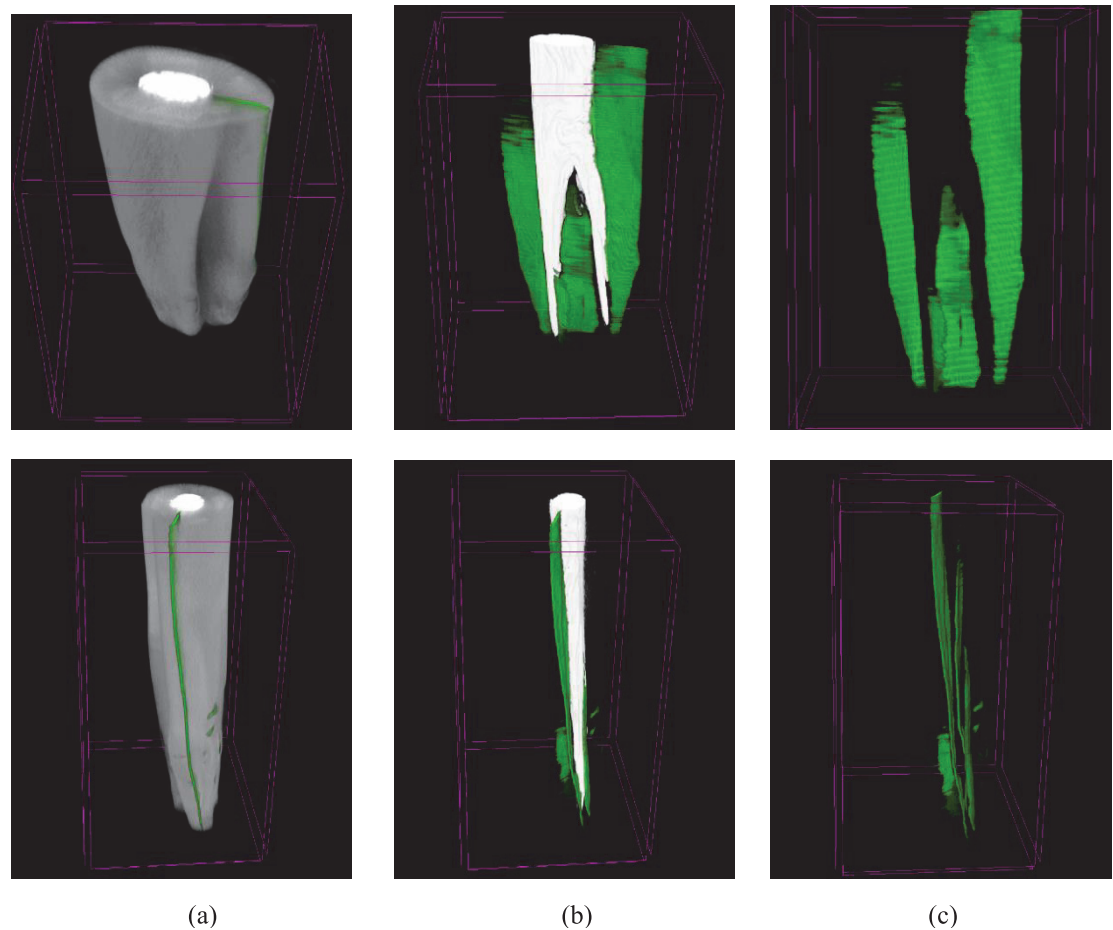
An example of combining Micro CT images with model-predicted results in CTvox. The part indicating cracks is highlighted in green. (a) is the combined image of both. (b) is the internal structure seen after adjusting the opacity transfer function of (a). The white parts represent the filling material within the tooth pulp chamber. (c) is the structure of cracks.
